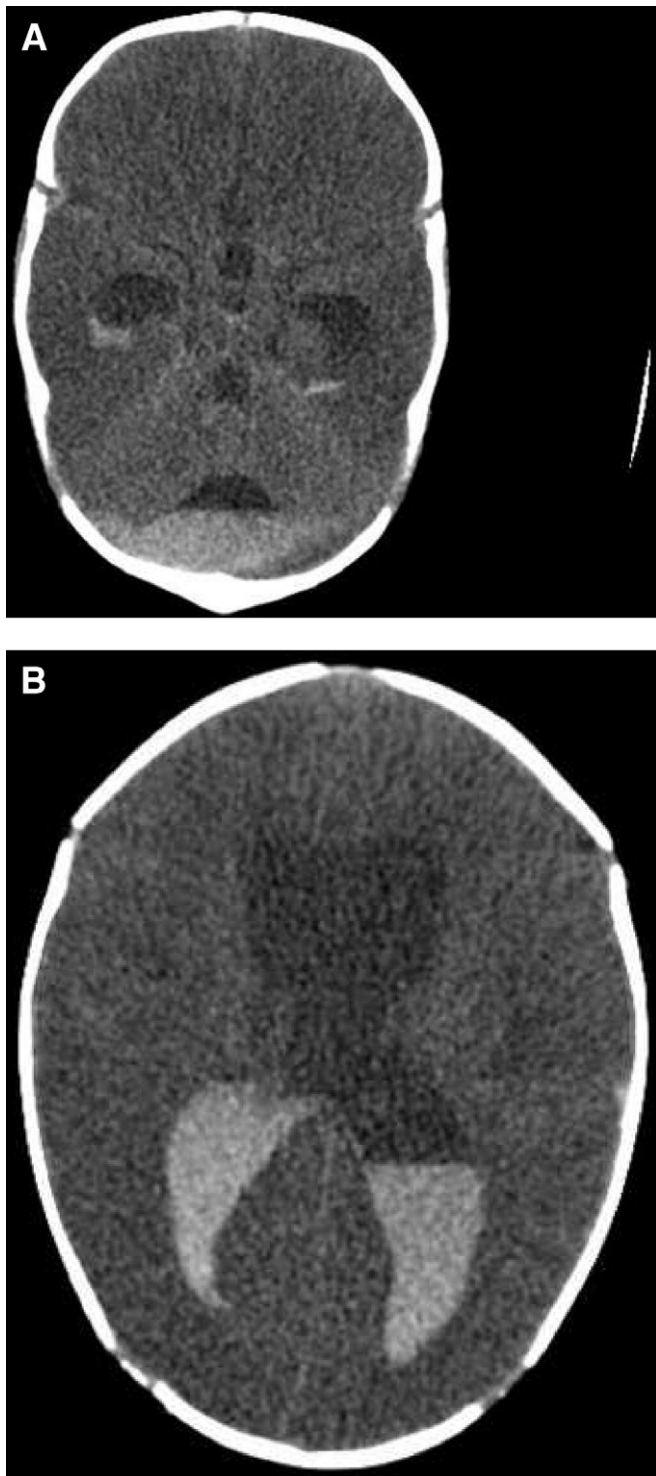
A, B, Head CT showed intraventricular hemorrhages, diffuse cerebral edema, and loss of the gray-white matter interphase.
